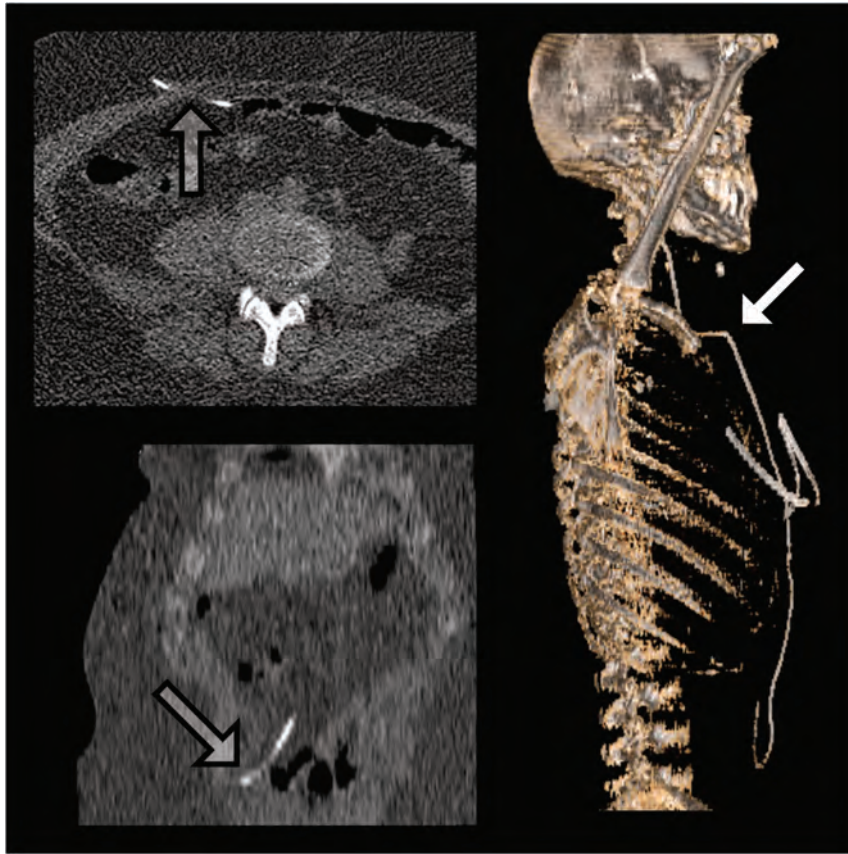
A 33-year-old woman presented with progressive headache, nausea, and vomiting, indicating a shunt dysfunction. Several shunt revisions were needed during infancy. The 3D reconstruction of the current WD-ULD-CT (right) depicts kinking of the shunt tube at the right clavicle (white arrow) as well as a short distal catheter in relation to an adult body size. However, the distal catheter passed through the peritoneum (transparent arrows on axial and coronal reconstructions on the left) and ends intraperitoneally.
